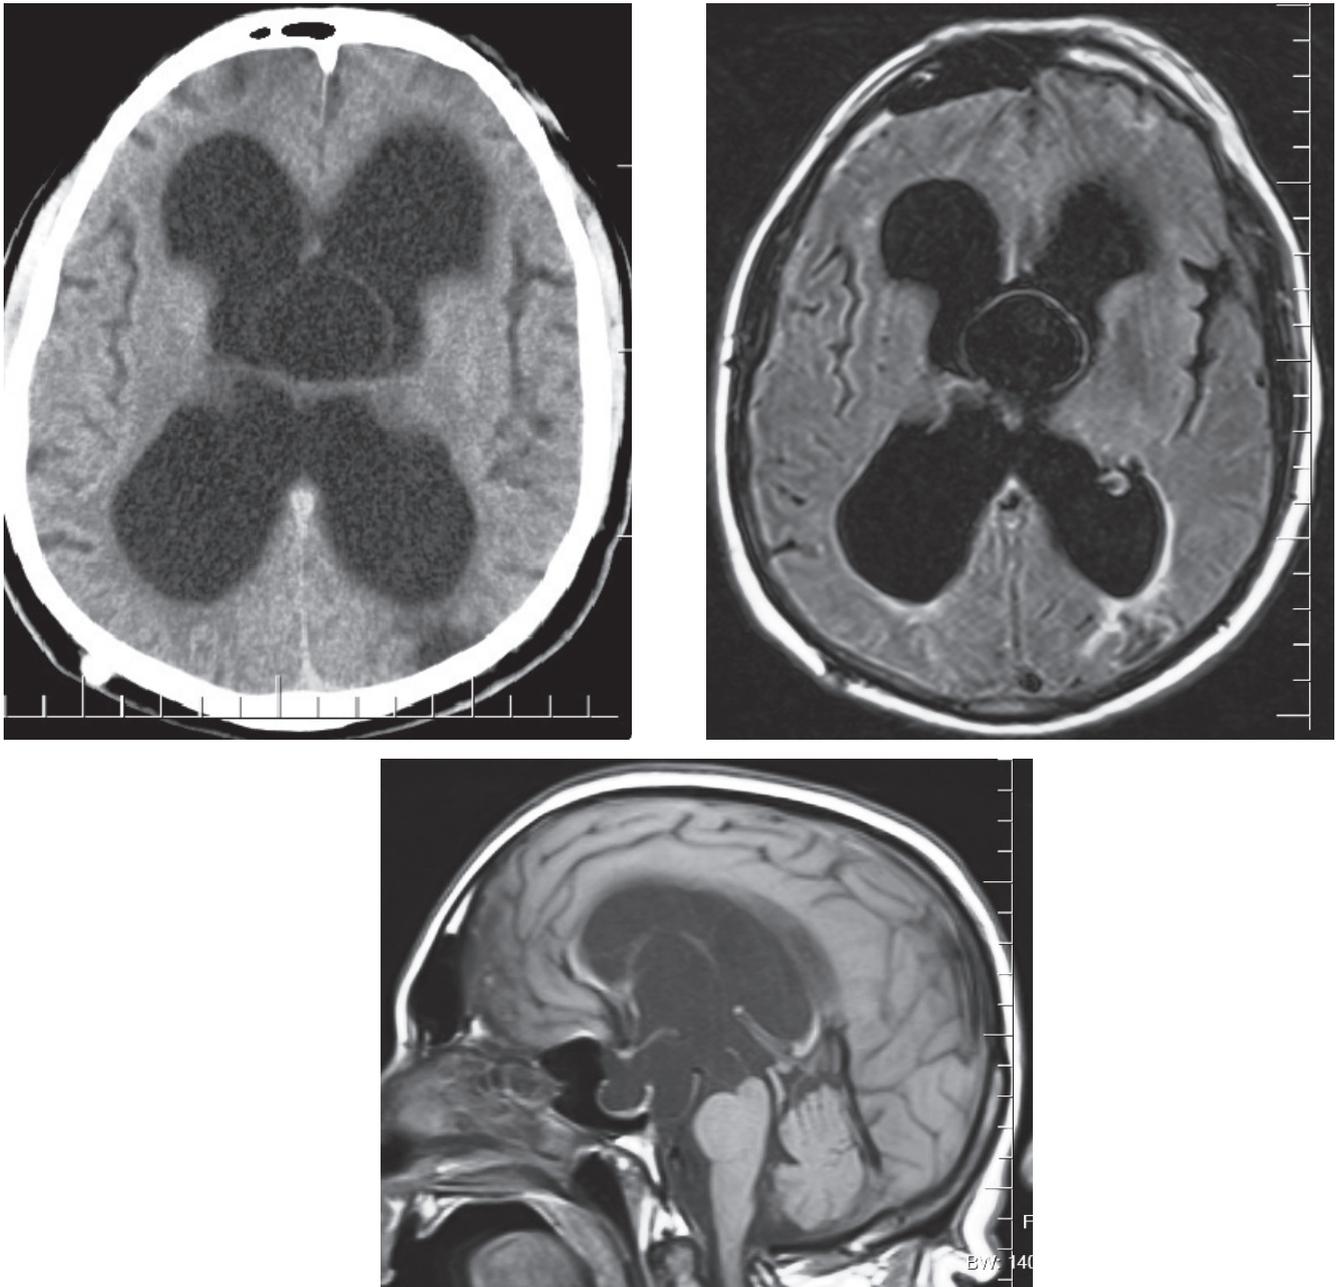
Preoperative cranial axial CT scan (a), preoperative cranial axial (b) and T-1 weighted sagittal (c) MRI scans demonstrating third ventricle arachnoid cyst and hydrocephalus.
